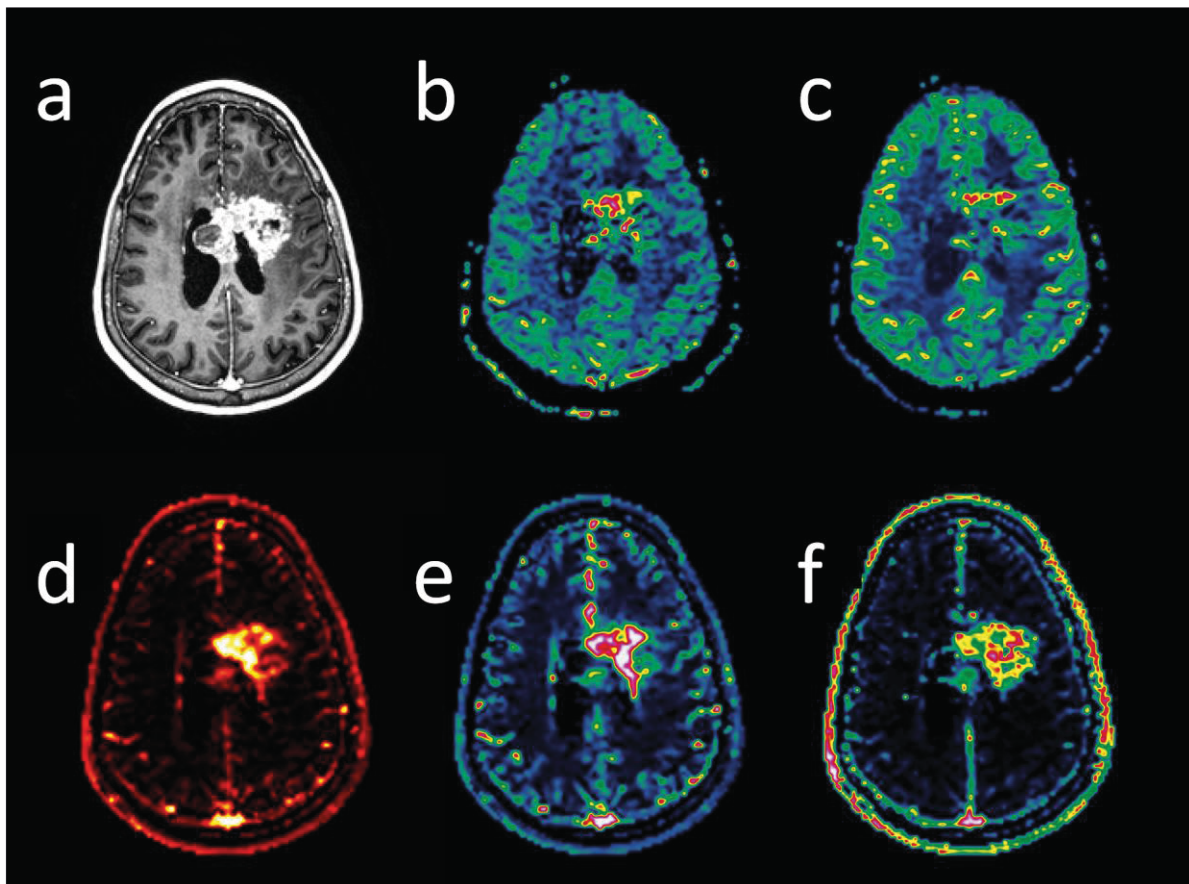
Structural image (a) and estimated parameter maps (b-f) of a patient from the thesis. Structural CE T1w image of the tumor is shown in a. Estimated parameter maps of rCBF and rCBV from DSC-MRI are shown in b and c respectively. From DCE-MRI estimated parameter maps of K^{trans} , CBF and v_e are shown in d, e and f respectively.
